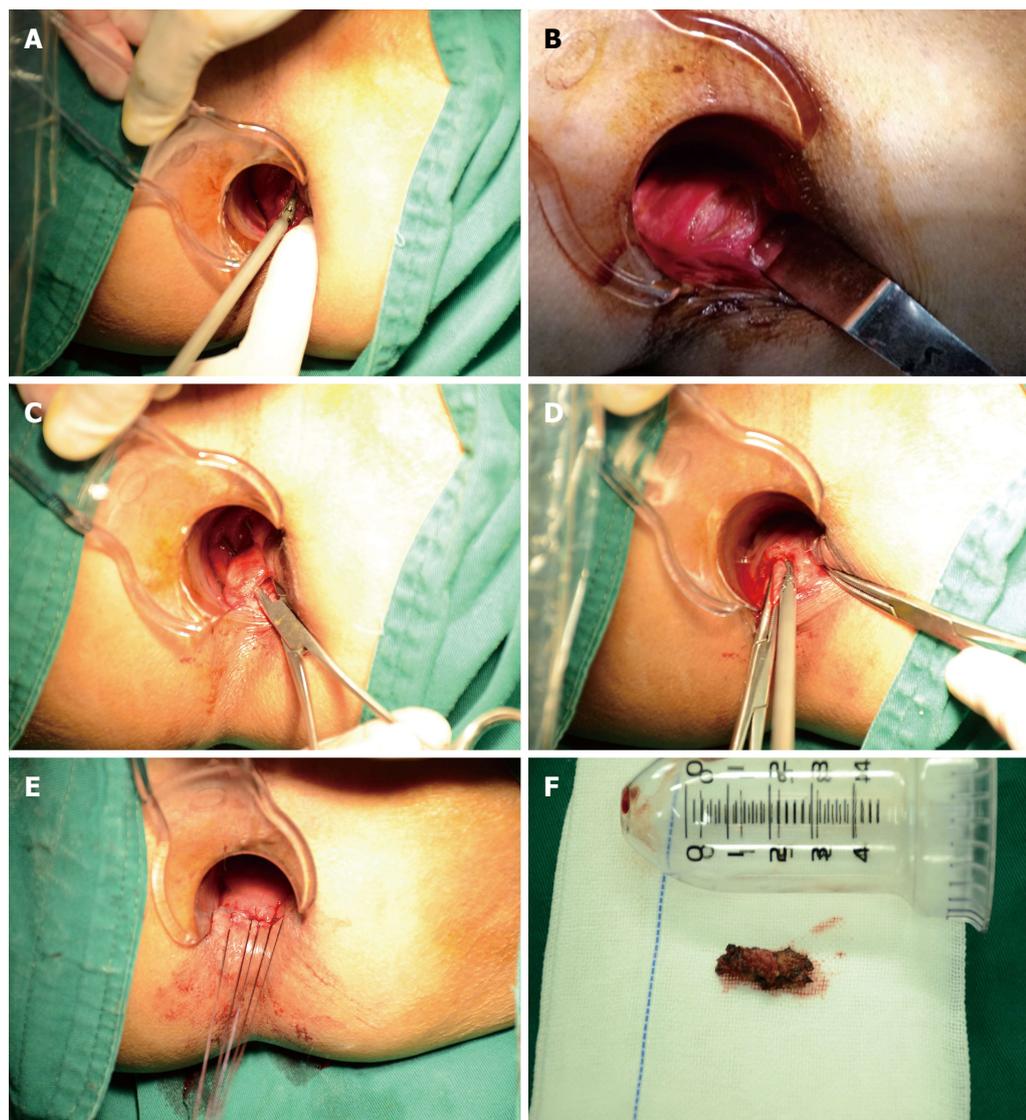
Technique of transanal partial excision of the puborectalis. A: Making a lateral incision of approximately 3 cm located 1 cm up on the dentate line on the rectal mucosa from the 3 o'clock direction to the 5 o'clock direction using an ultrasound knife; B: The rectal postero-lateral wall was dissected to the puborectalis; C, D: The puborectalis muscle was lifted up and approximately 2 cm was removed with an ultrasound knife; E: A full-thickness suture of the rectal wall was carried out; F: The resected sample.
